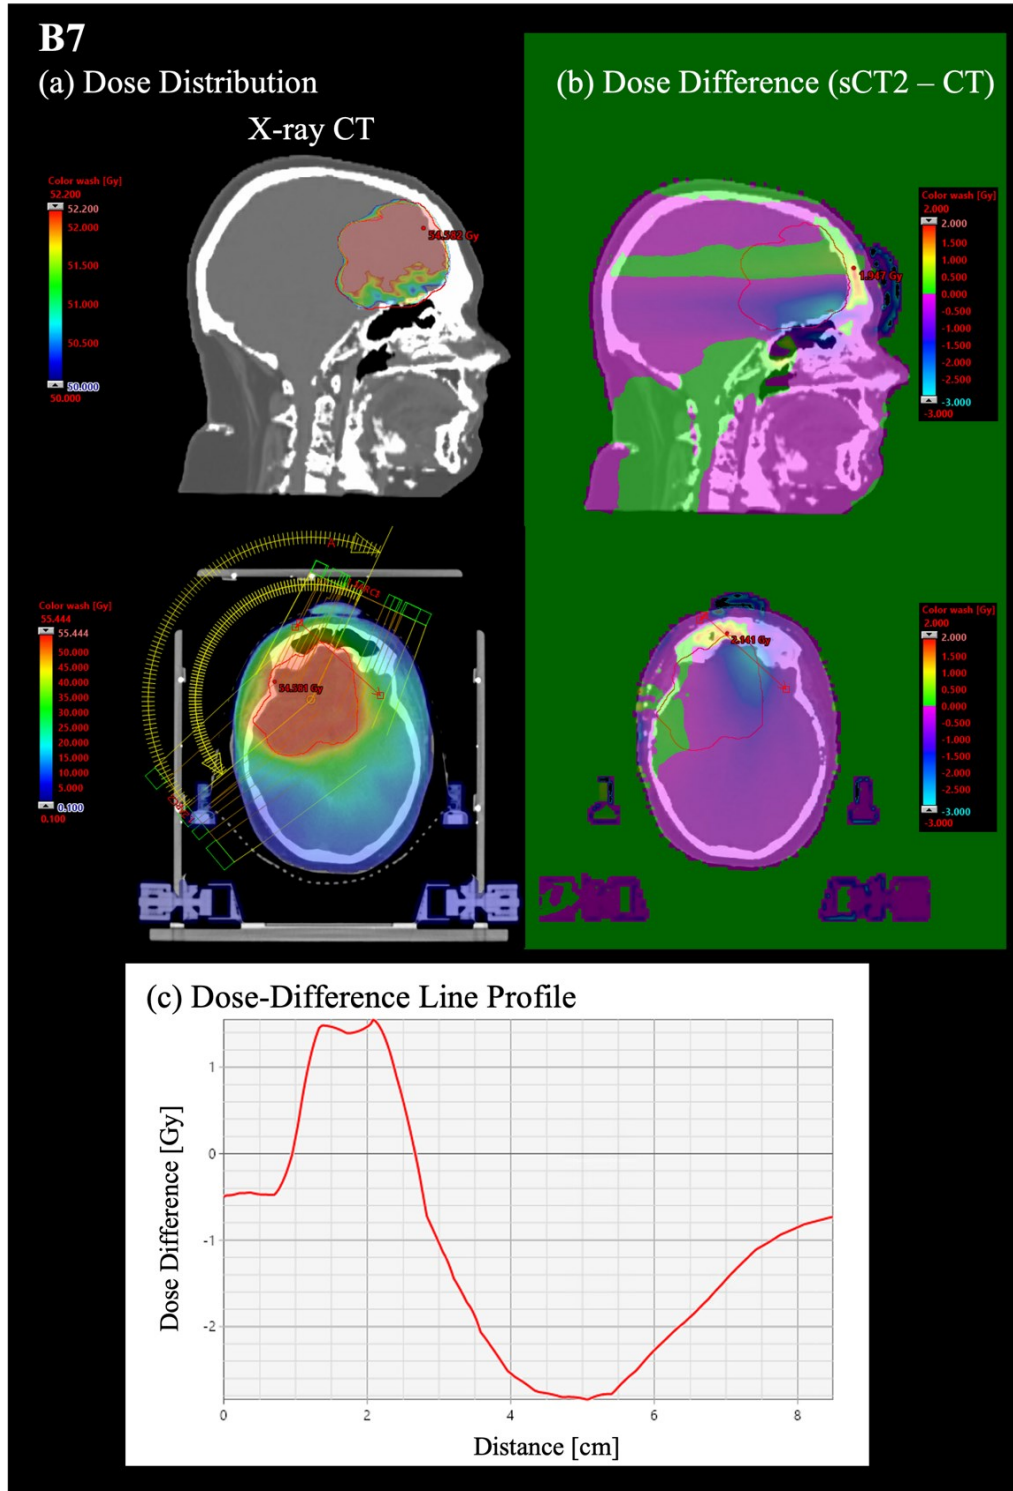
(a) Dose distribution of X-ray CT and (b) dose difference map of sCT2 for patient B7. The frontal sinus was erroneously replaced by bone structures and beams pass through these regions, causing more attenuation of the beams. (c) Dose line profile along the red line on the X-ray CT and sCT2 images, showing too much attenuation inside the frontal sinus and dose reduction posterior to the region of the frontal sinus.
